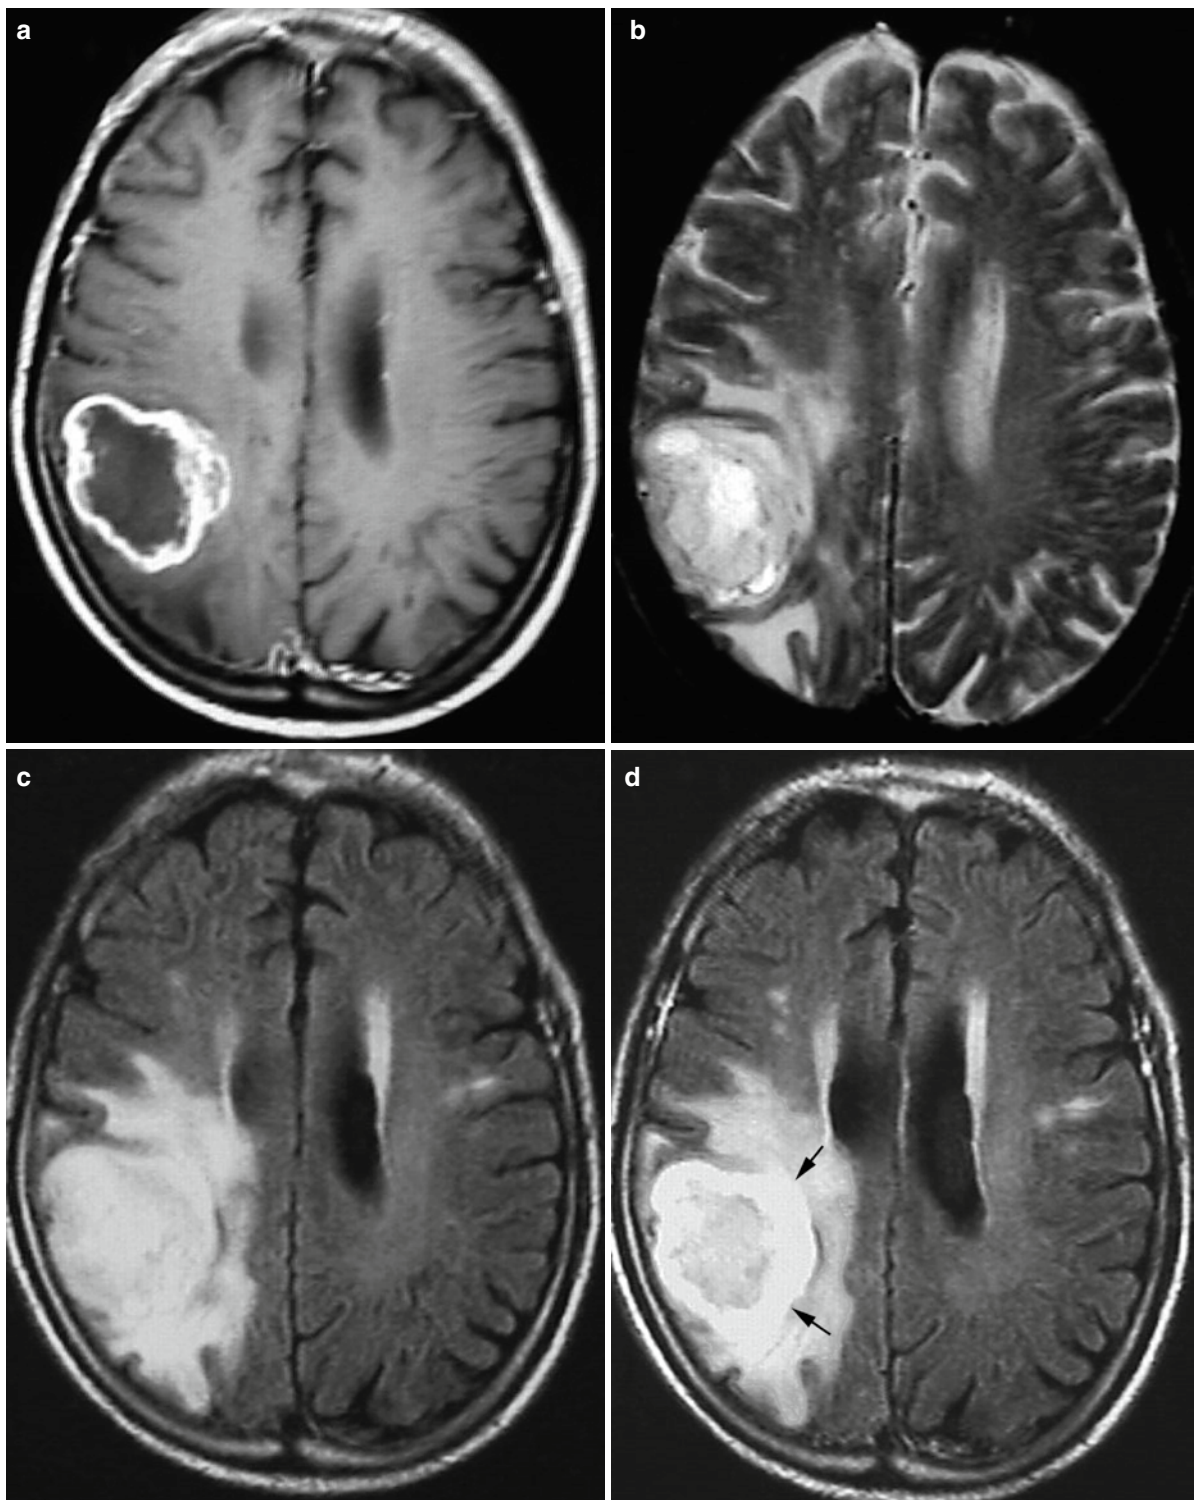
Left parietal glioblastoma. (a) Post-contrast T1WI shows an irregular ring-like enhancement. (b) T2WI shows a high signal mass surrounded by peritumoral edema (c) FLAIR image shows the mass and the peritumoral edema which is more
